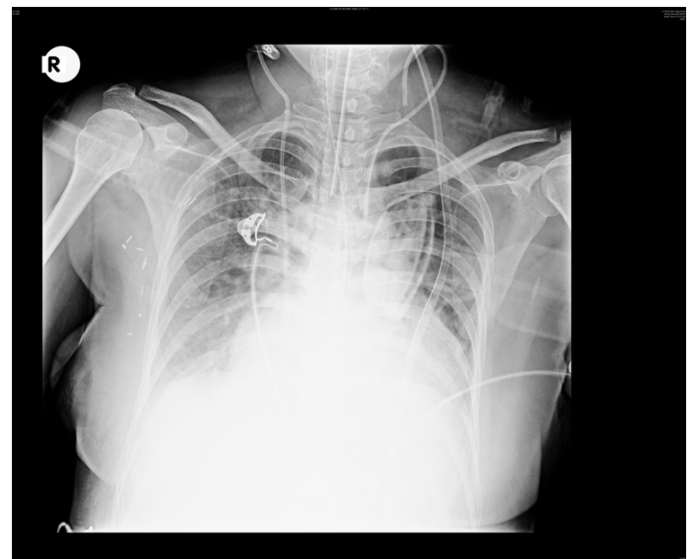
Chest X-ray showing left sided central line catheter not crossing midline. Right sided IJV central line catheter seen in situ.
